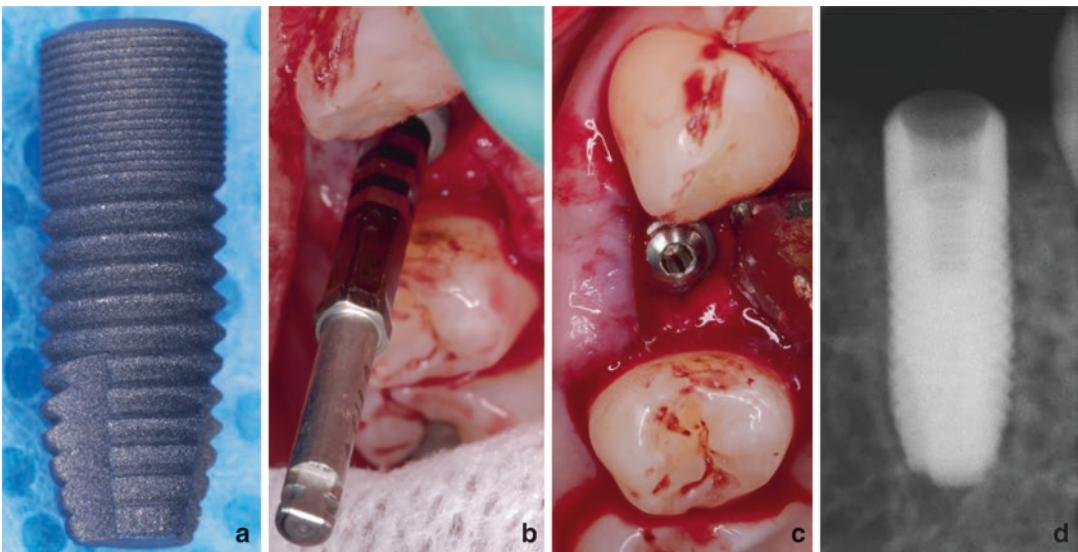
Stages of implant placement. (a) Implant fixture, (b) insertion of the implant into the bone, (c) position of the implant between two adjacent teeth, and (d) radiograph of the successfully placed implant
